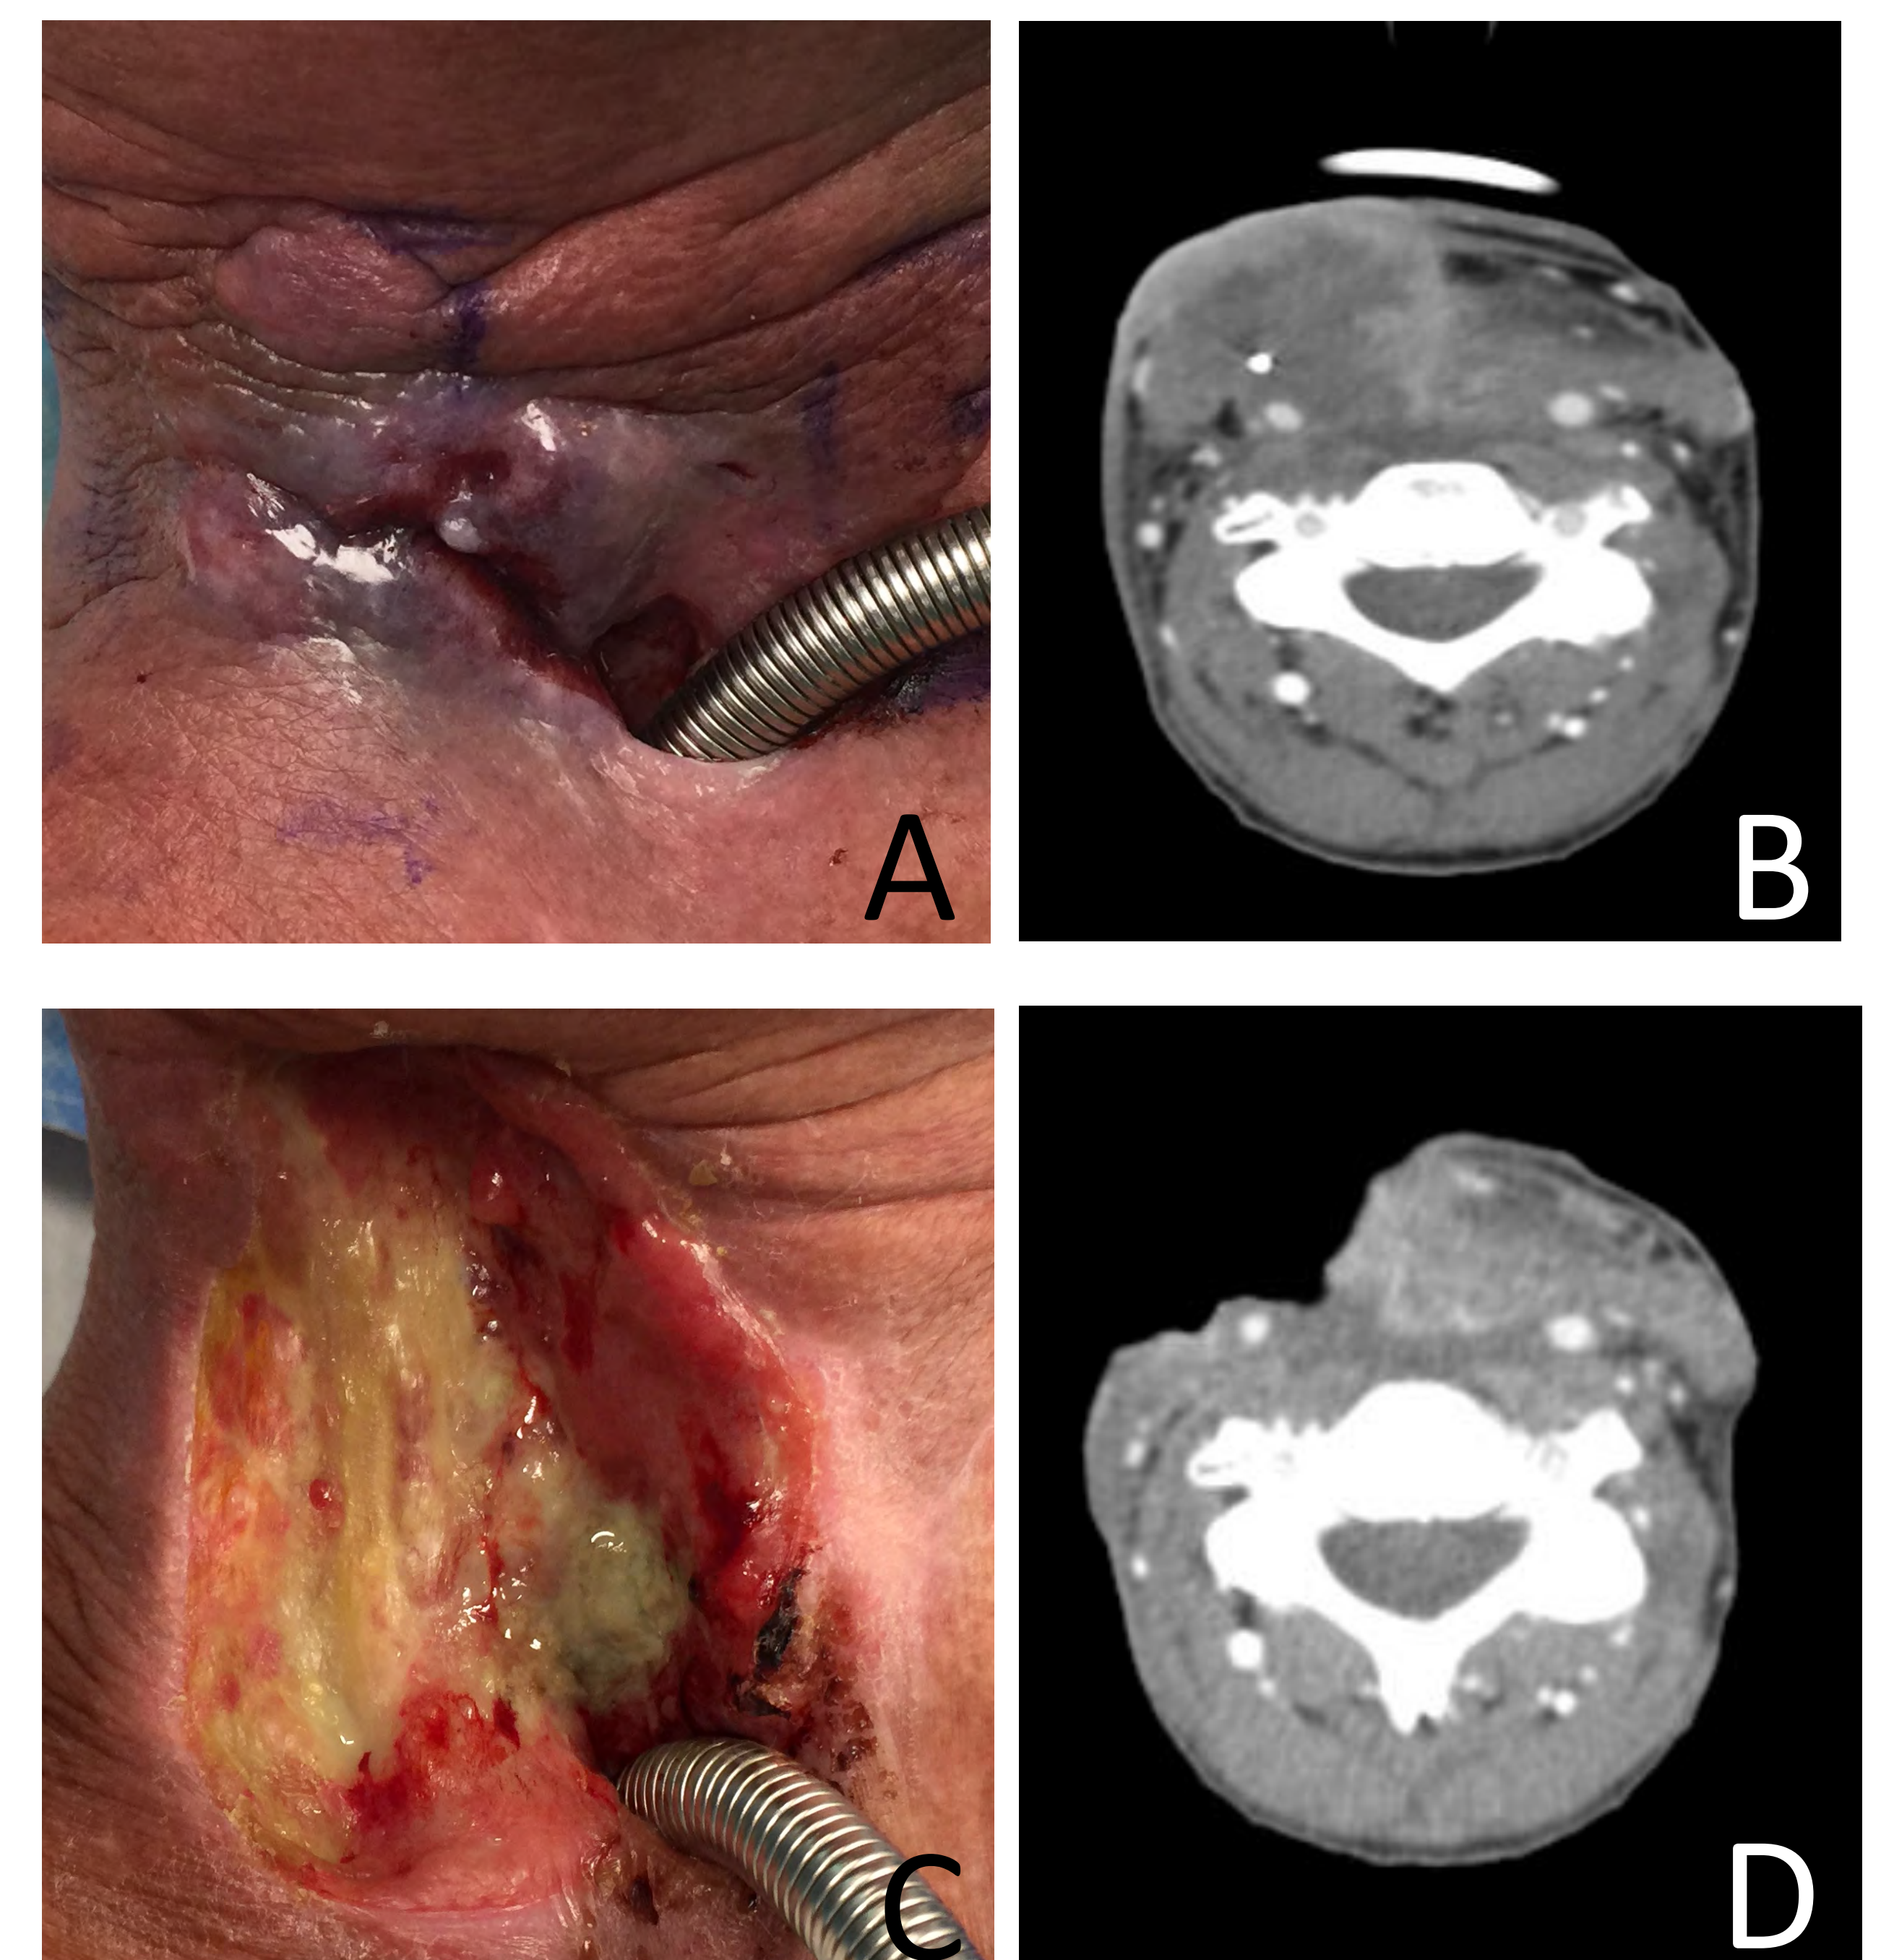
59 YOF patient with history of salvage laryngectomy for recurrent squamous cell carcinoma who developed peristomal recurrence then enrolled in the Aspyrian trial. Photographs show (A) pre-treatment appearance of stoma and (B) pre-treatment CT scan, (C) 6 weeks post-treatment appearance of stoma and (D) 6 week post-treatment CT scan.
